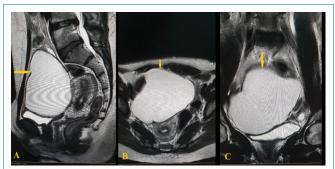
Magnetic Resonance Imaging (MRI) revealed a right adnexal mass of eleven cm with slightly hypointense signal intensity on T1-weighted and intermediate to high signal on T2-weighted (arrow). (A): Sagittal section (B): Transverse section (C): Frontal section.
